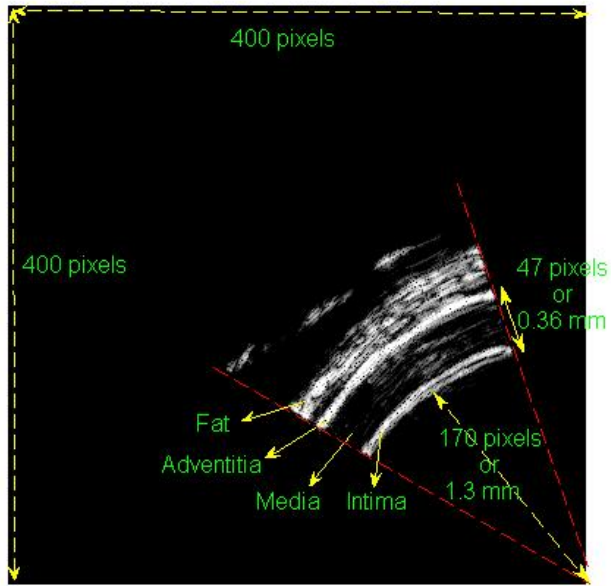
Ultrasound image of the coronary vessel wall at 30 mmHg
